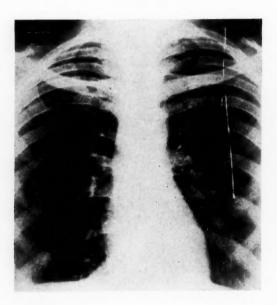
Roentgenogram, anterior-posterior view, in Case 1 about three weeks after that in Fig. 2, showing that the slight bulging of the mediastinal shadow at the sternal notch had disappeared.
